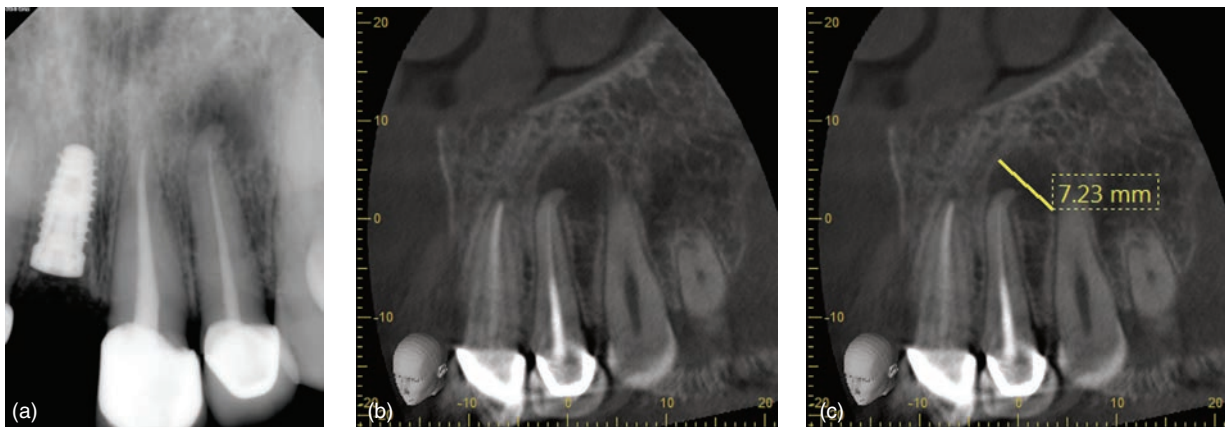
Previously treated maxillary lateral incisor with apical periodontitis. (a) Periapical radiograph showing crown restoration and root canal filling. Apical radiolucency is visible on the radiograph. (b) Sagittal view confirms apical sharp curvature. Root canal filling is not following the apical curvature. (c) Sagittal view showing a larger low-density area compared to periapical radiograph. Due to severe apical curvature, surgical retreatment was chosen.
